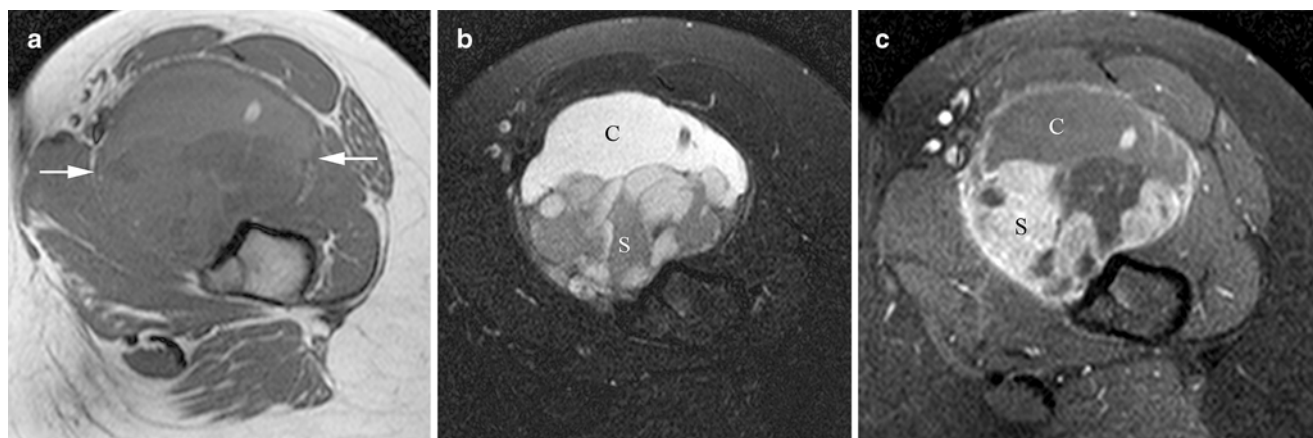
In this patient with a synovial sarcoma the (a) non-contrast-enhanced T1W axial magnetic resonance image shows mixed signal intensity of the tumor (arrows) while the (b) T2W fat-saturated image
